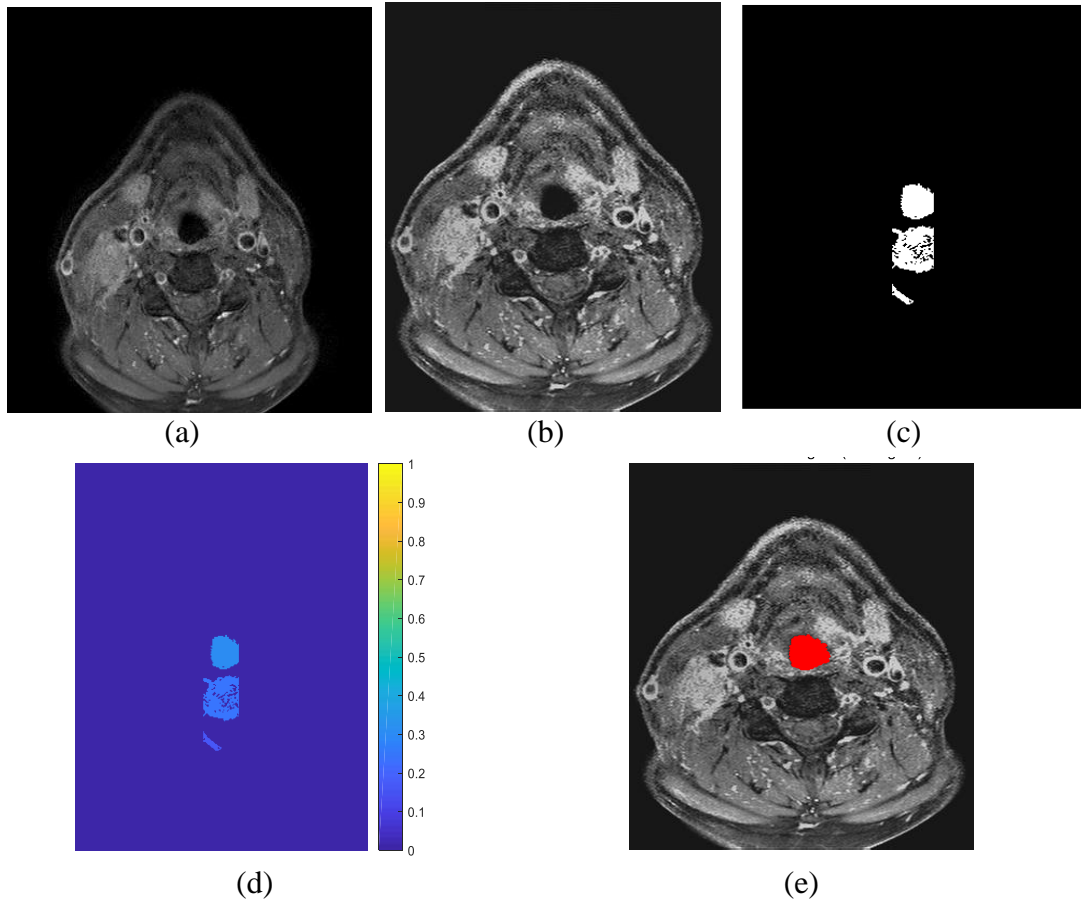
(a)(b) shows an original and pre-processed MRI slice (from MR28082014), (c) is the selected binary image  $B_I$ , (d) is the possibilities of each region in  $B_I$  to be throat region, and (e) shows the detected throat region on slice which is marked as red.
